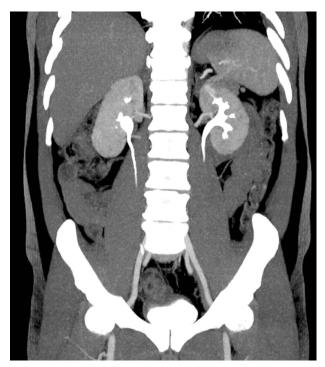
Computed tomography of the abdomen and pelvic after 6 months of starting and 2 month after cessation of oral voriconazole showing excretion to the pyelocalyceal system from the left kidney and complete relief of the hydronephrosis.
